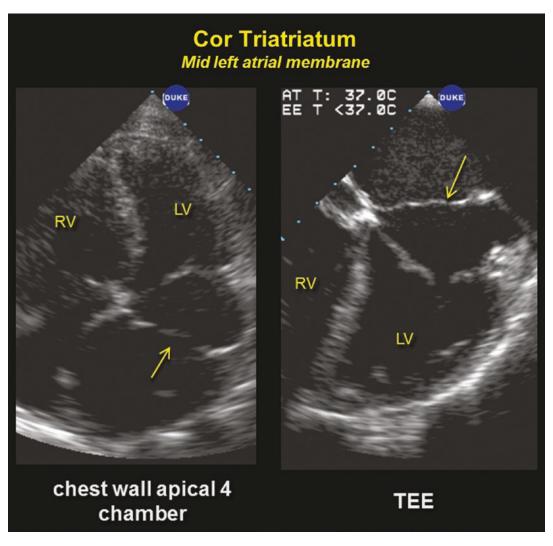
A membrane of cor triatriatum is seen in the apical four chamber view (arrow, left panel) and the transesophageal (right panel)
